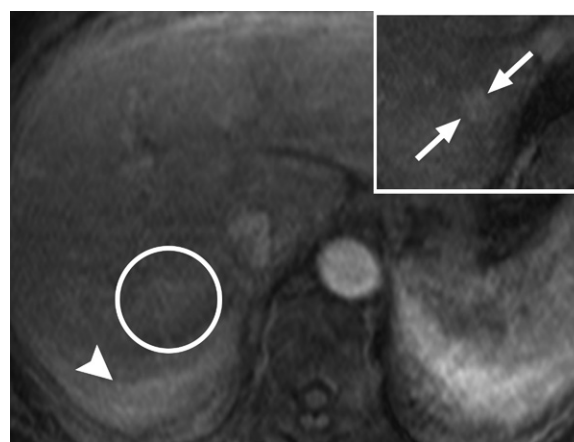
Transient arterial phase motion seen with use of gadoxetate contrast agent in a 64-year-old woman. Axial T1-weighted arterial phase MR image is degraded by respiratory motion artifact (arrowhead), creating ambiguity as to whether nonrim APHE in a segment VII observation (circle) is truly present. Image from a repeat examination with an extracellular agent (inset) confirms nonrim APHE (arrows) in a LI-RADS 5 HCC.
